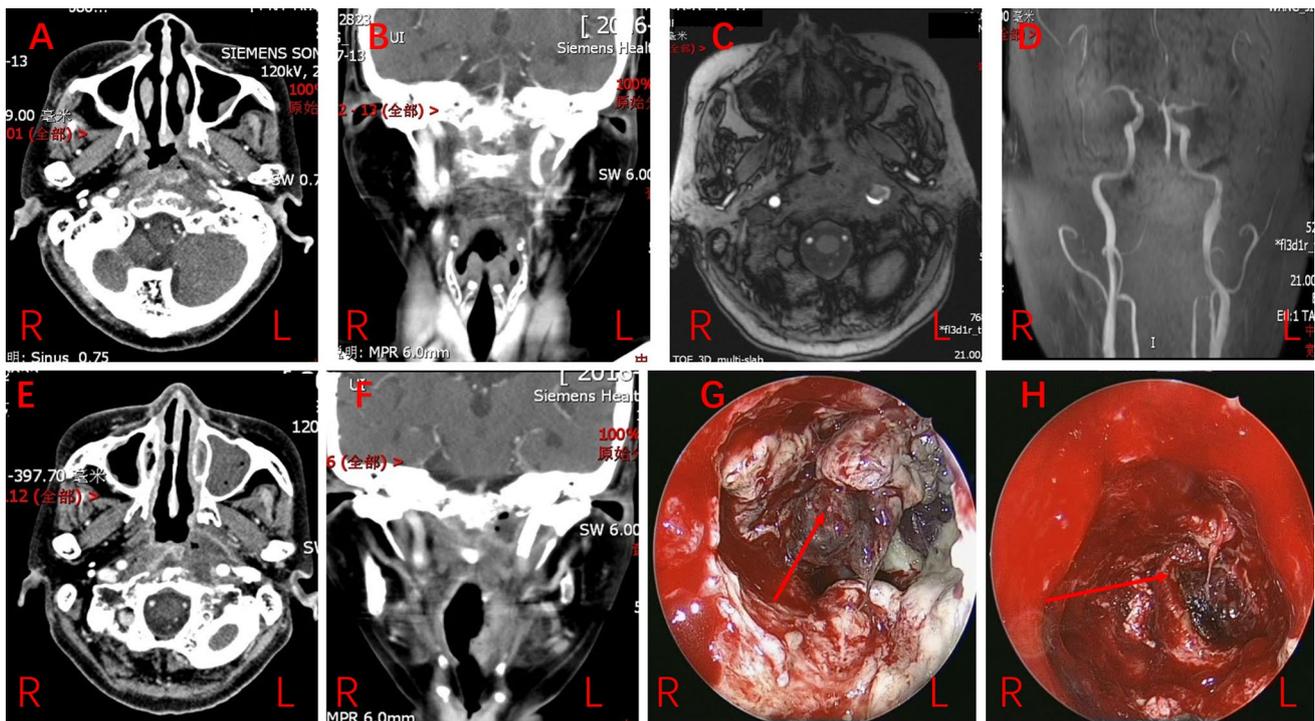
a–d The necrotic tissues and a pseudoaneurysm of the left ICA by CT and MRA. e, f Images of CT after balloon angioplasty and implantation of 2 PTFE-covered stents in the ICA. g, h The necrotic tissues in the surgery
